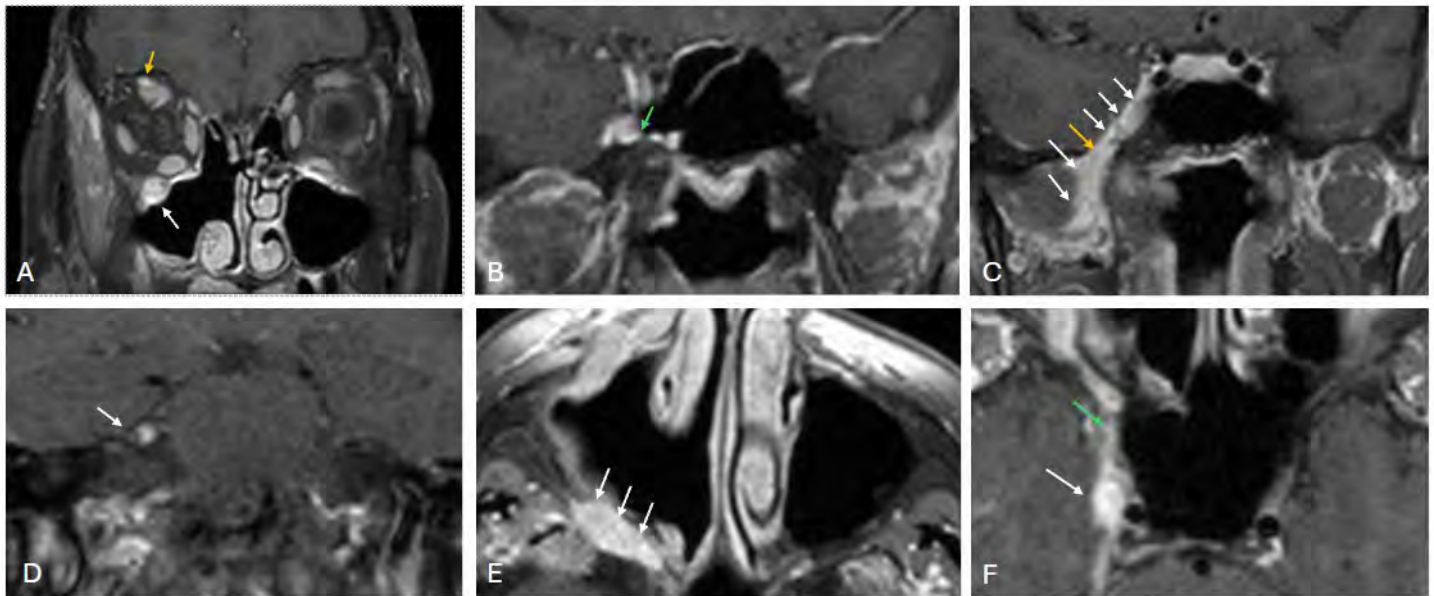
Coronal (A–D) and axial (E–F) contrast-enhanced fat-suppressed T1-weighted MR images demonstrating perineural spread of melanoma along the right maxillary nerve (V2). (A) Enlargement and enhancement of the right infraorbital nerve with extension of abnormal signal and soft-tissue infiltration (white arrow). The right supraorbital nerve also shows enhancement, indicating secondary perineural spread along V1 (yellow arrow). (B) Enlargement of the right foramen rotundum (green arrow) (C) Thickening and enhancement of the V3 segment extending through the foramen ovale (yellow arrow). (D) Abnormal enhancement of the cisternal segment of the right trigeminal nerve (white arrow). (E) Enhancement of the right pterygopalatine fossa (white arrows). (F) Enlargement and enhancement of Meckel's cave (white arrow) and the foramen rotundum (green arrow).
